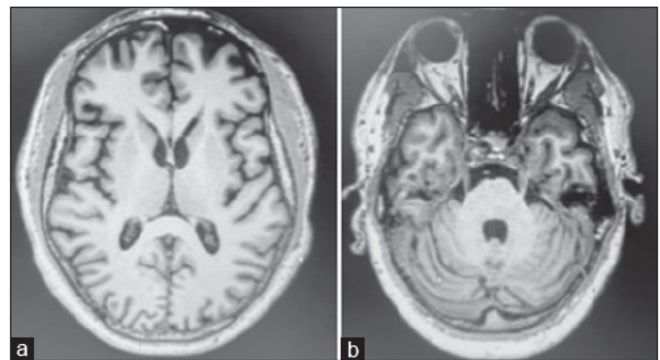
Axial T1W magnetic resonance imaging of the brain shows mild diffuse cerebral atrophy (a) and cerebellar atrophy (b). T1W = T1-weighted
